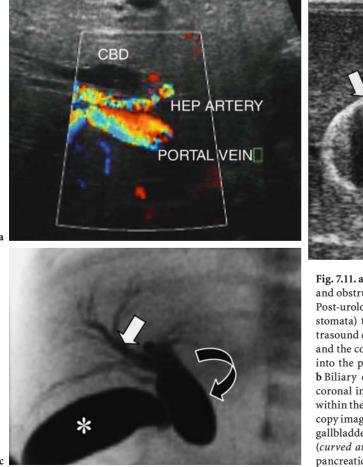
a A 3-week-old boy with a history of urethral valves and obstructive ureters (diagnosed on prenatal ultrasound). Post-urological intervention (placement of bilateral sober stomata) the baby developed progressive jaundice. The ultrasound exam reveals dilation of the intrahepatic bile ducts and the common bile duct (CBD), which could be visualized into the pancreatic head. The gallbladder was also dilated. b Biliary drainage via the dilated bile duct. The obliquecoronal image shows an Amplatz guidewire (*arrow*) placed within the gallbladder (*asterisk*). c Post-intervention fluoroscopy image shows the dilated intrahepatic bile ducts (*arrow*), gallbladder (*asterisk*) and the dilated common bile duct (*curved arrow*). The latter is blind ended at the level of the pancreatic head. At surgery a choledochal cyst was found
